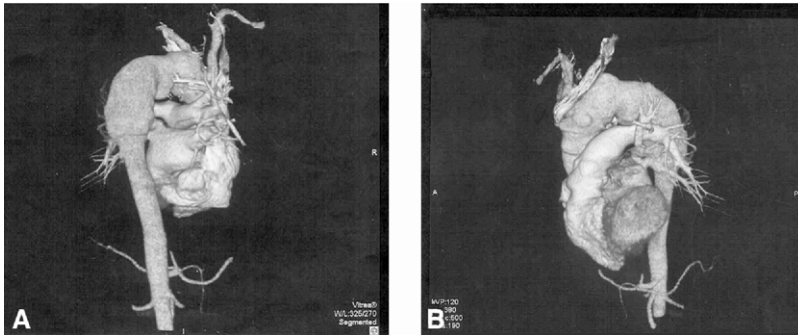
Three-dimensional preoperative computed tomographic scan of the thoracic aorta showing the complex aortic aneurysm. A, posterior view; B, left lateral view.
